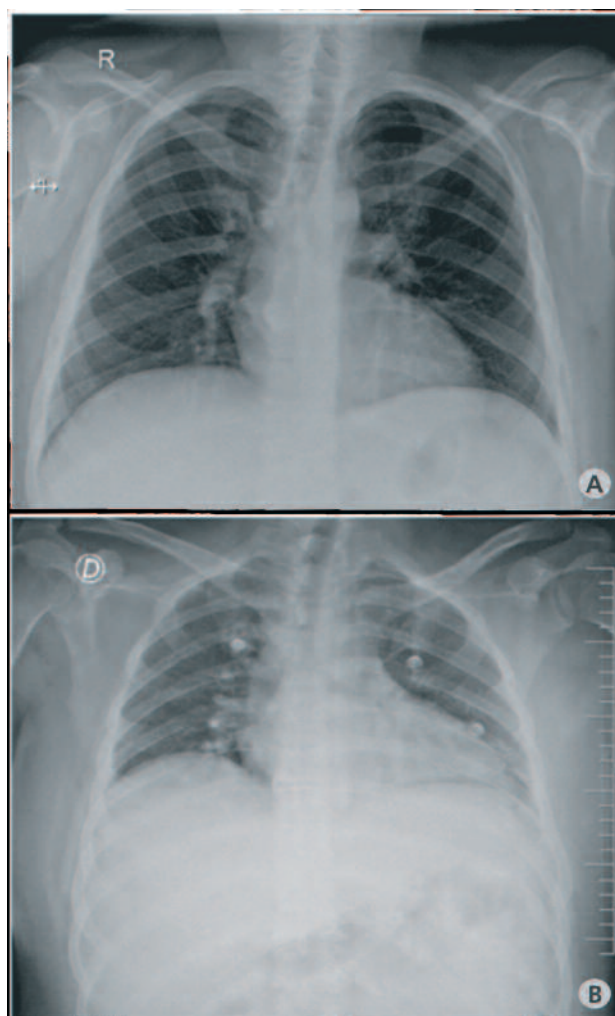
Chest x-ray: A. Normal chest radiography 48 hours prior to decompensation. B. Acute phase with shock symptoms and new sudden cardiomegaly.
